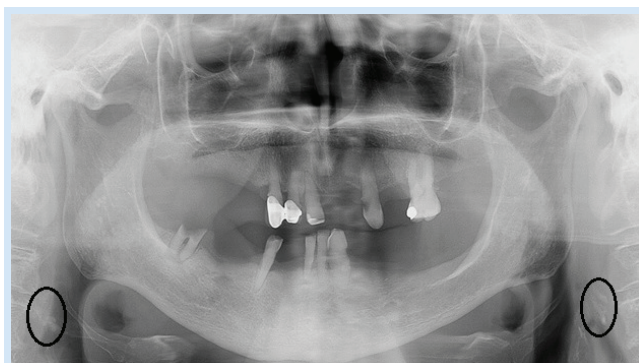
Orthopantomograph showing calcifications in projection of carotids, suggestive of calcified atherosclerotic plaques.
